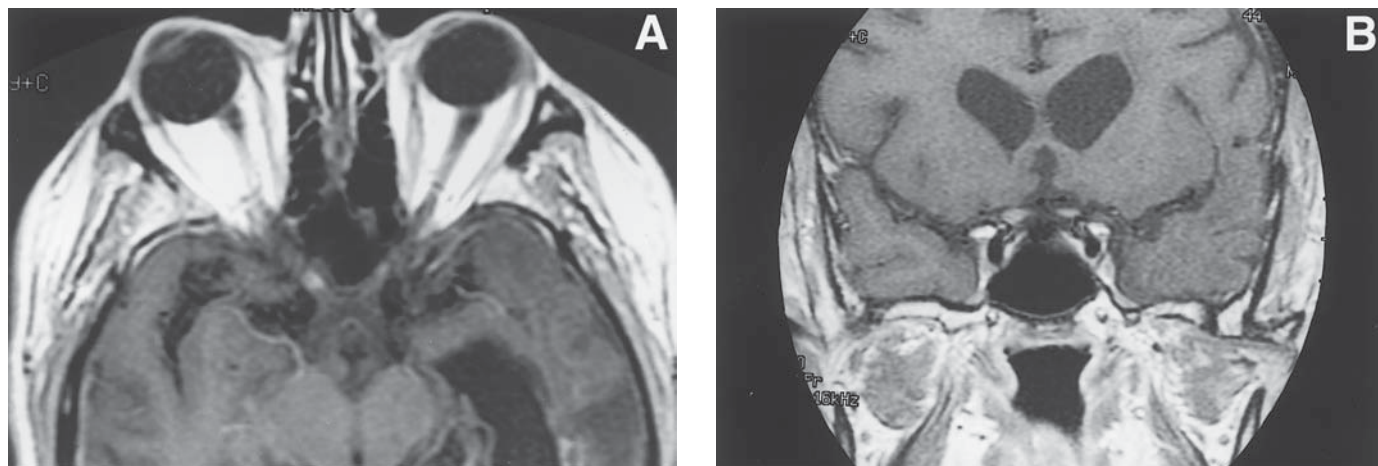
MRI axial and coronal T1-weighted sequences showing enlargement and gadolinium enhancement of the prechiasmatic optic nerves after cranial RT in a 44-yr-old man. The patient became progressively blind, and the follow-up scan revealed chiasmatic atrophy 4 yr after RT.
